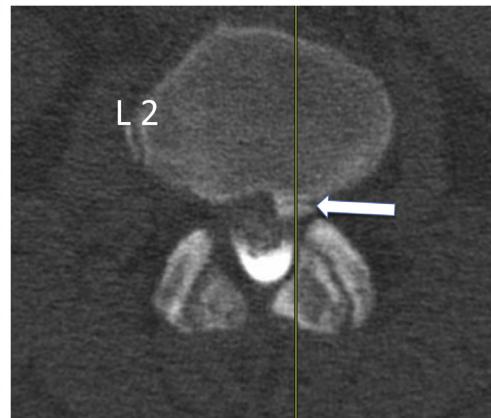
Computed tomography myelogram performed before L2–L3 decompression, (Left) midsagittal and (Right) axial views showed posterior marginal osteophyte at L2 (arrow). The L2 vertebral body showed no erosion.
